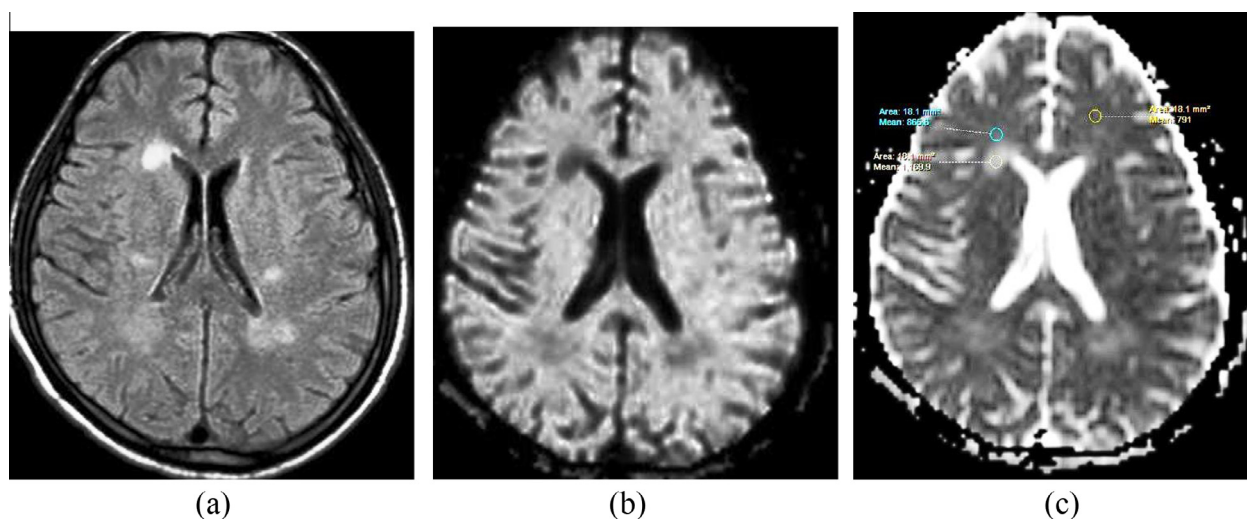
37 year-old male with RRMS, no relapse for 9 months and no cognitive impairment (MOCA score 28). (a) Axial FLAIR showed multiple plaques, (b) DWI image showed signal intensity of facilitated diffusion, (c) ADC map showed the following readings: Plaque 1.699×10^{-3} , Periplaque 0.8656×10^{-3} , and NAWM $0.791 \times 10^{-3} \text{ mm}^2/\text{s}$.
